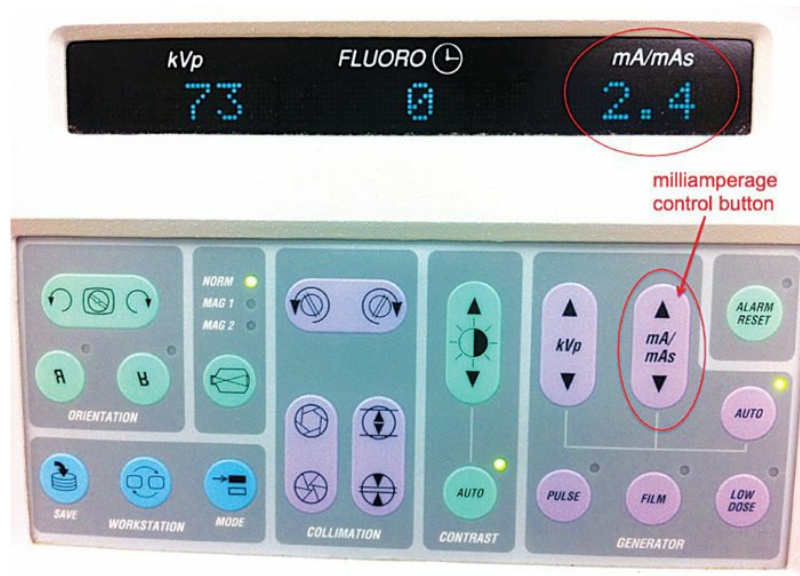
The amount of current supplied to the *x-ray tube* is measured in milliamps (mA) and determines the *density* and *intensity* of the *x-ray beam*.
